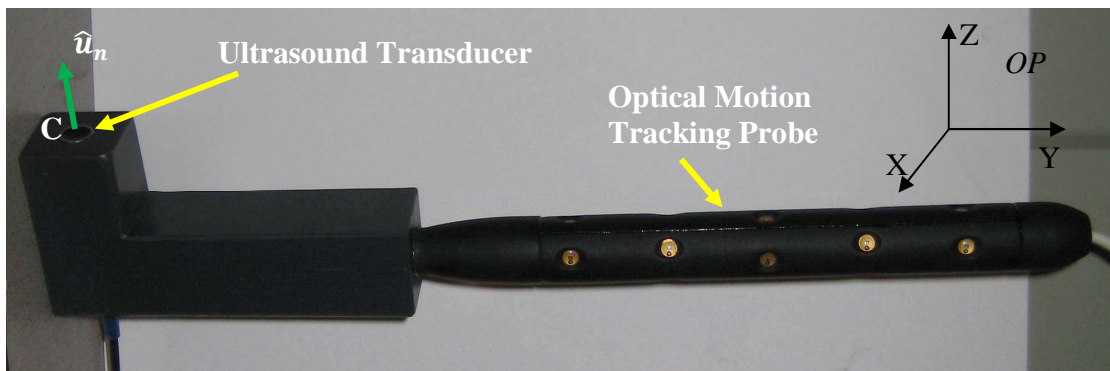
The tracked single-element (A-mode) ultrasound probe showing the optical motion tracking probe, the A-mode ultrasound transducer rigidly attached to it, the optical probe's local coordinate frame (OP) and the calibration parameters
